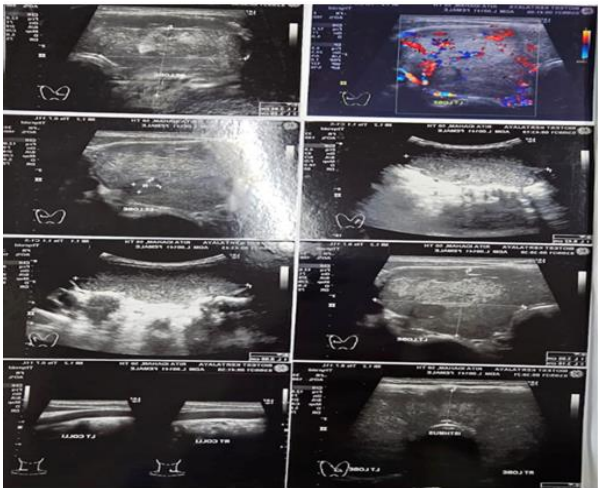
Ultrasonography on September 3, 2021, at biotest clinic surabaya
